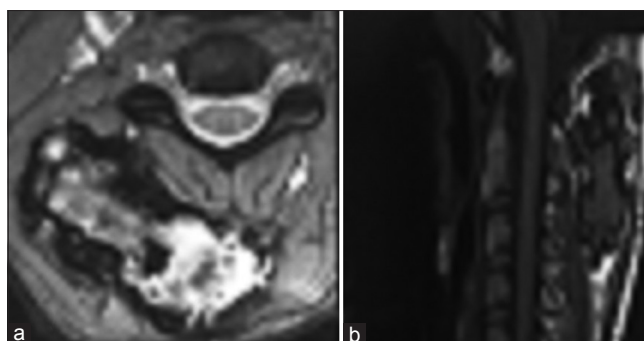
(a and b) Axial and sagittal sections of magnetic resonance imaging showing enchondroma of the atlas
